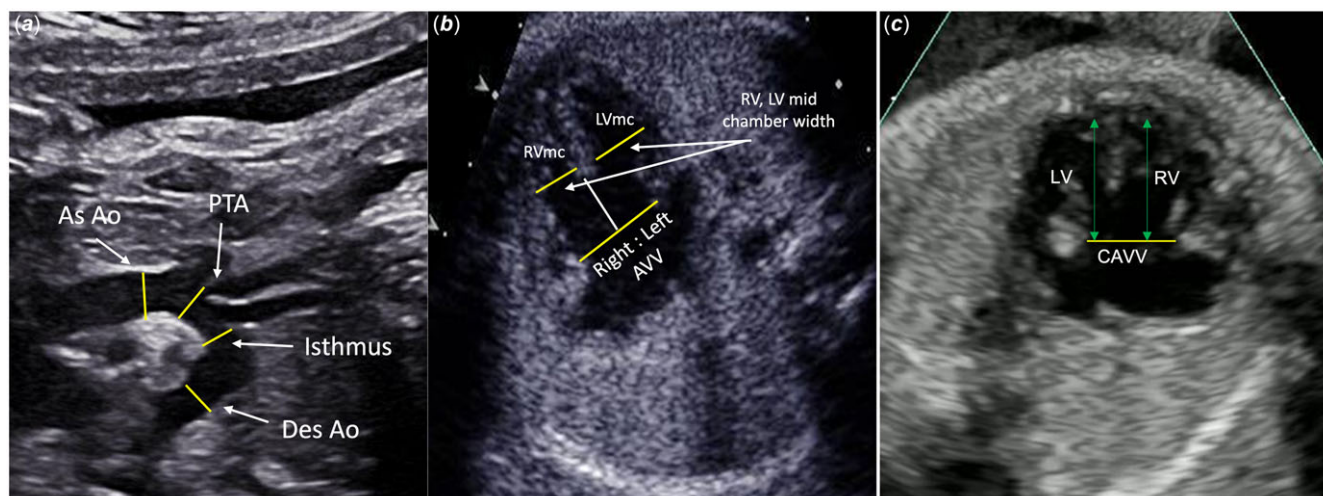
Fetal echocardiographic measurements in atrioventricular septal defect. 1A: aortic arch measurements: as. Ao = ascending aorta, PTA = proximal transverse aortic arch. 1B: intracardiac measurements: rvmc = right ventricle mid-chamber width, lvmc = left ventricle mid-chamber width. Right: left AVV = right and left diameter of the common atrioventricular valve. 1C: intracardiac measurements: LV = left ventricular length, RV = right ventricular length, CAVV = common atrioventricular valve.
